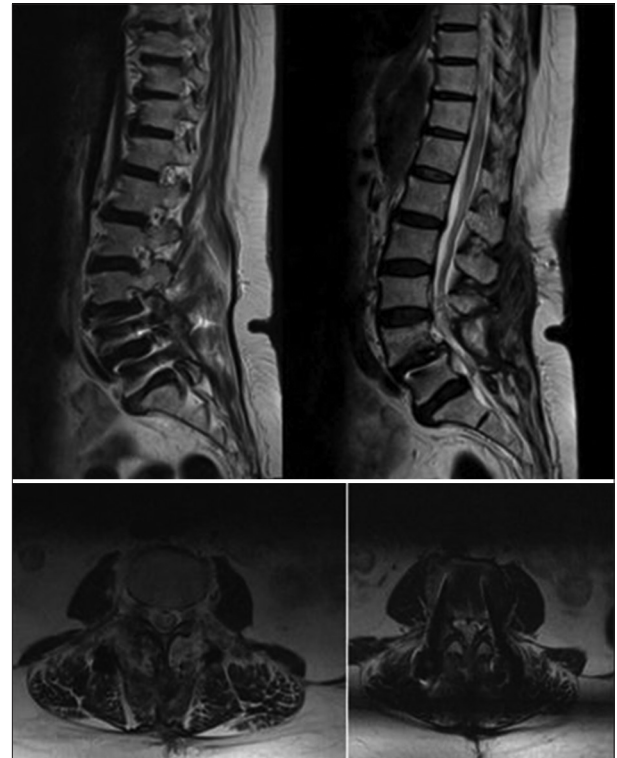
Pre-operative magnetic resonance imaging – sagittal view suggestive of grade 1 L4/L5 listhesis with moderate-to-severe stenosis. In axial view-diffuse disc bulge at L4/L5 causing compression of the central cord and bilateral foramina with facet and ligamentum hypertrophy
